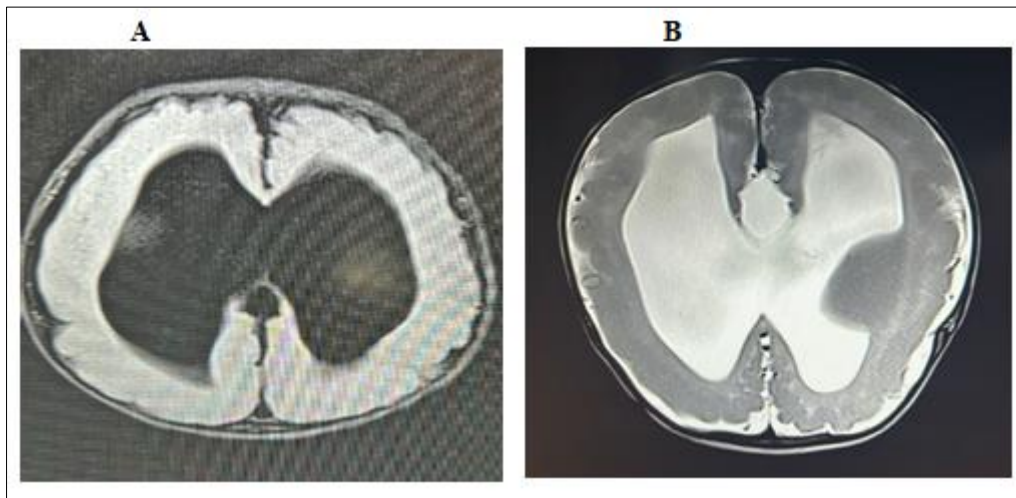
A & B: Axial FLAIR and a T2-weighted axial MRI images showing dilation of the lateral ventricles and fused basal ganglia with poor definition of internal capsule
